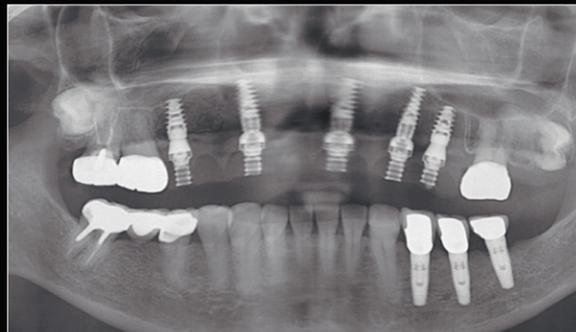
Post-operative panoramic XRAY
